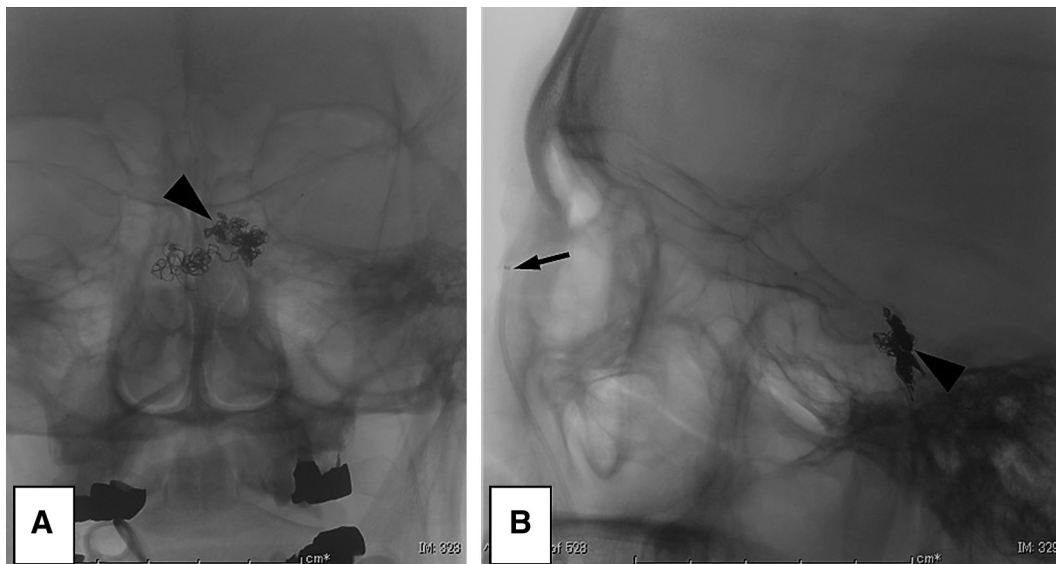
Postoperative plain skull radiography (A: antero-posterior view, B: lateral view) showing additionally delivered coils (arrowheads) during the second session of TVE. The tip of the Tactics intermediate catheter (arrow) was placed in the angular vein. TVE: transvenous embolization
